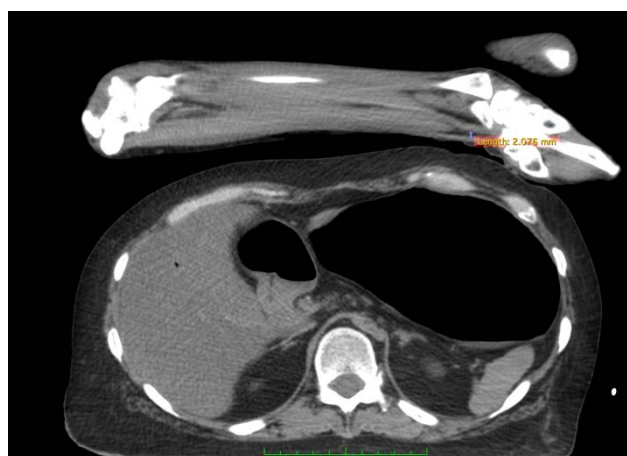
Example of upper extremity CT slice with coinciding right radial artery measurement label used for analysis
